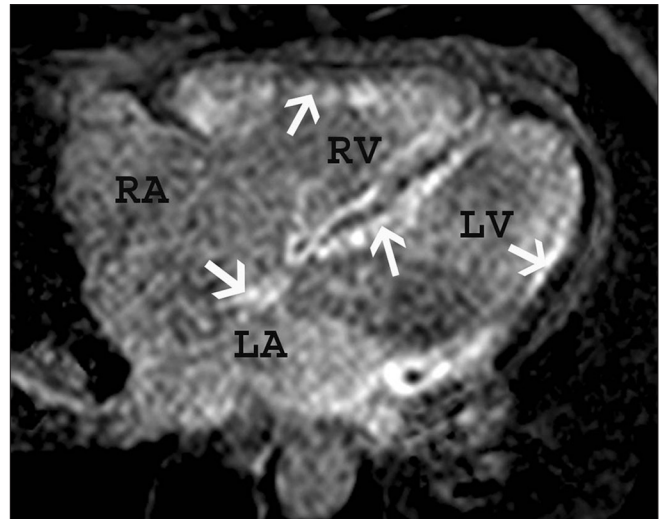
Cardiac amyloidosis. Four-chamber delayed-enhancement magnetic resonance imaging shows diffuse subendocardial enhancement (arrows) extending to the mid-myocardium, involving the entire left ventricle, right ventricle, interatrial septum, atrial walls, and valves, consistent with cardiac amyloidosis
